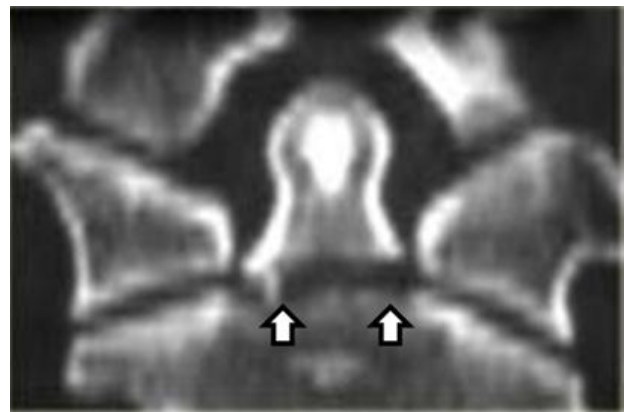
CT image of fracture of dens axis (type II)
